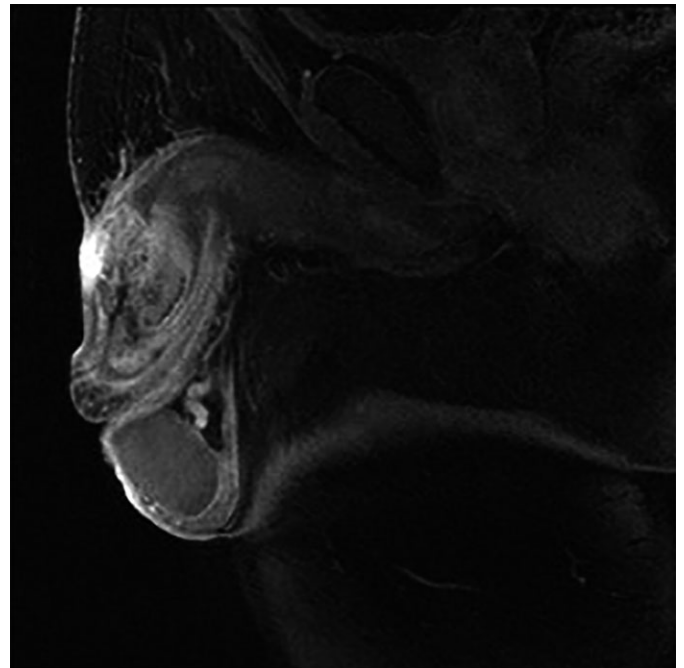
Post-contrast T1 sagittal MRI showing tumour involving the glans and distal corpora. Tumour abuts the urethra and radiological concern for early T3 disease was reported. Surgery confirmed T2b disease with no urethral infiltration.
